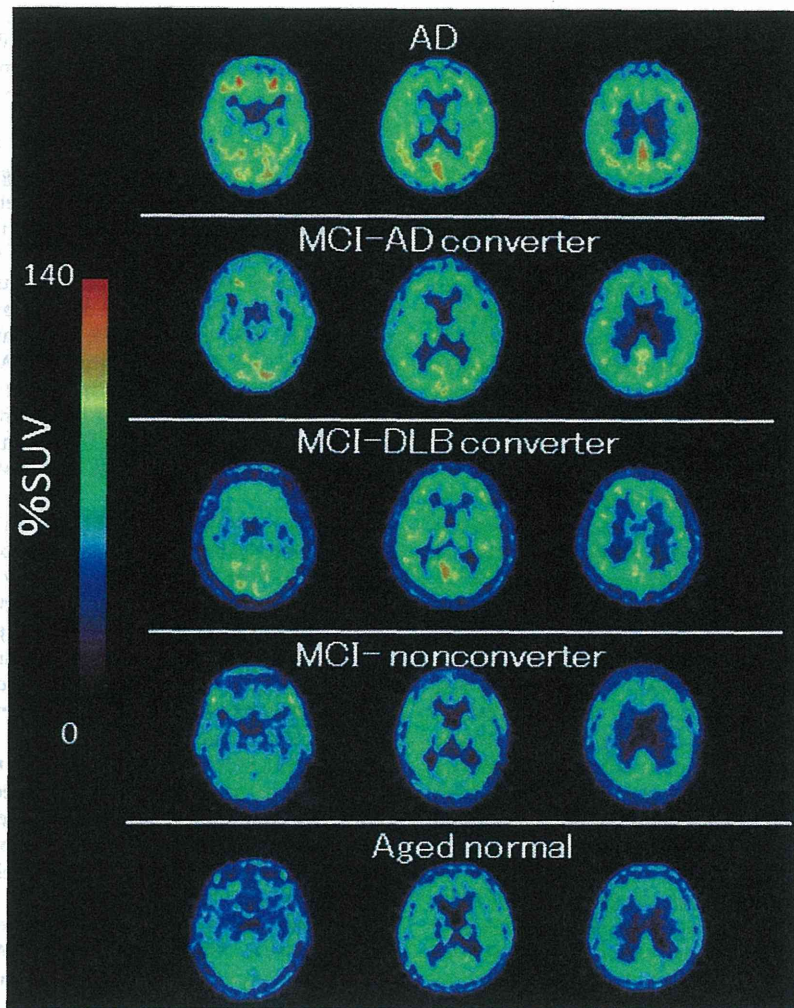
Mean %SUV images between 30 and 90 min after injection of [<sup>11</sup>C]DAA1106 of AD, MCI-AD converter, MCI-DLB converter, MCI-nonconverter and an aged normal subject.
